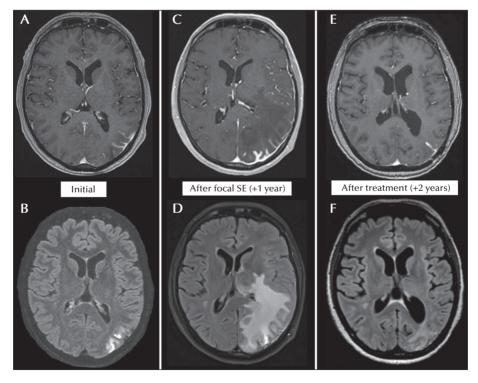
Brain MRI (all views are based on similar slice location). Upper row:(A, C, E): post-contrast T1-weighted images showing an increase in enhanced meningeal thickening in the left parietal aera after focal SE (C), followed by a decrease after treatment with rituximab (E). Lower row (B, D, F): post-contrast FLAIR images (FLAIR multiplanar reconstruction in [B]) showing a large vasogenic oedema within brain parenchyma underlying meningeal changes after focal SE (D). A gliotic scar was present at the last control (F).
